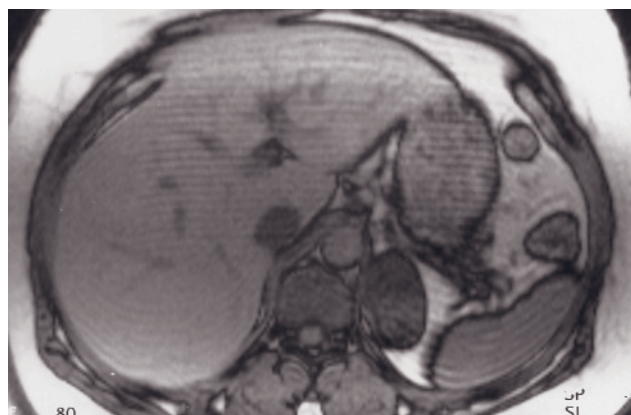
Large adrenal adenoma. T1-weighted GE (a), T1-weighted out-of-phase GE (b), immediate postgadolinium GE (c), and 90-s postgadolinium fat suppressed GE (d) images. A right adrenal mass appears hypointense to the liver on T1 GE image (a) and does not drop signal on T1 out-of-phase image (b). There is a heterogeneous capillary blush after contrast administration (c), which diminishes moderately and remains slightly hypointense on late images (d).
